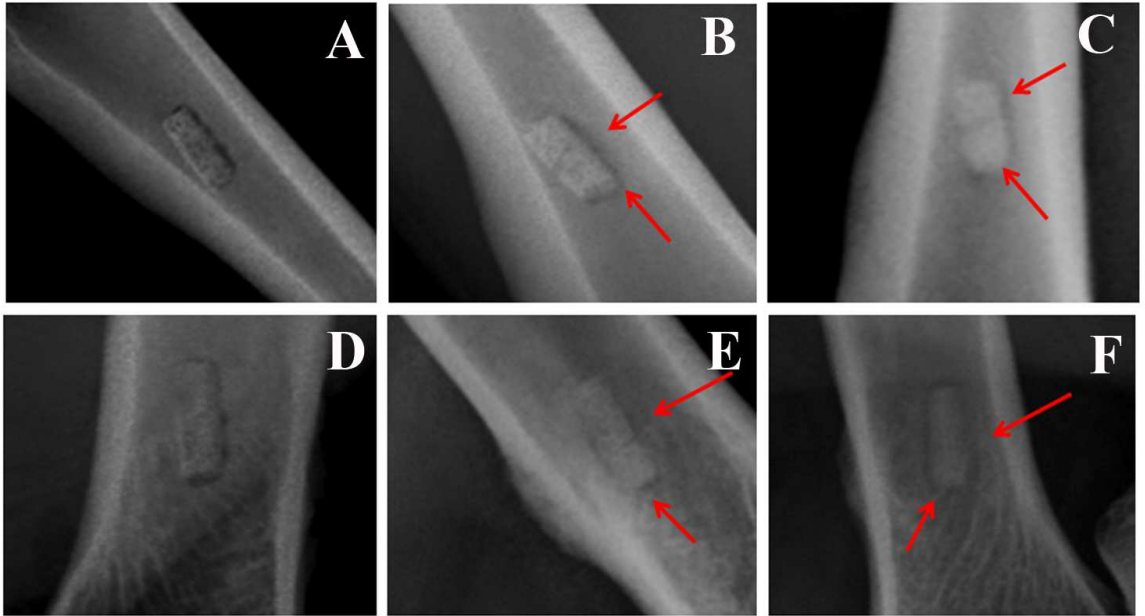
Evaluation of osteointegrative ability of the scaffolds – HA & cHA: Radiographs depict indicating the osteointegration ability post 0, 1, 2 months of implantation in HA (A-C) cHA (D-F). (Red arrow heads indicate poor osteointegration at bone implant interphase).
